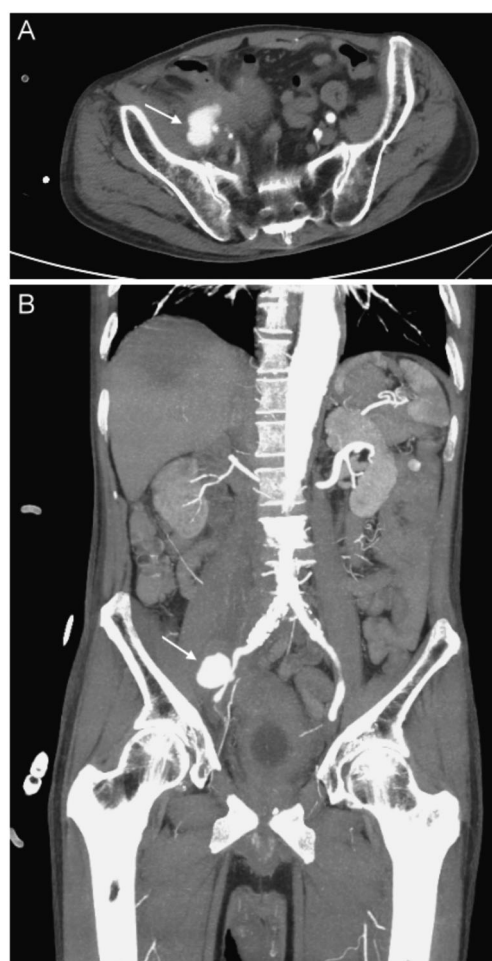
CTA (Computed tomography angiography) protocol showing (A) a pseudoaneurysm of $\approx 3.2 \times 2.7$ cm in the right external iliac artery (EIA). (B) Coronal plane of the same patient revealing inflammatory changes of the right psoas muscle, urinary bladder, and nearby terminal ileum (arrows)
